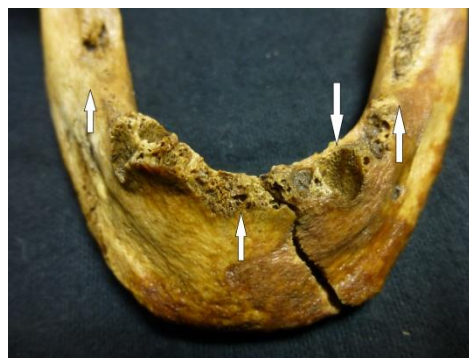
Mandible of skeleton 60 showing recent anterior AMTL and more advanced AMTL of molars (upwards arrows) and a periapical abscess (downwards arrow).
